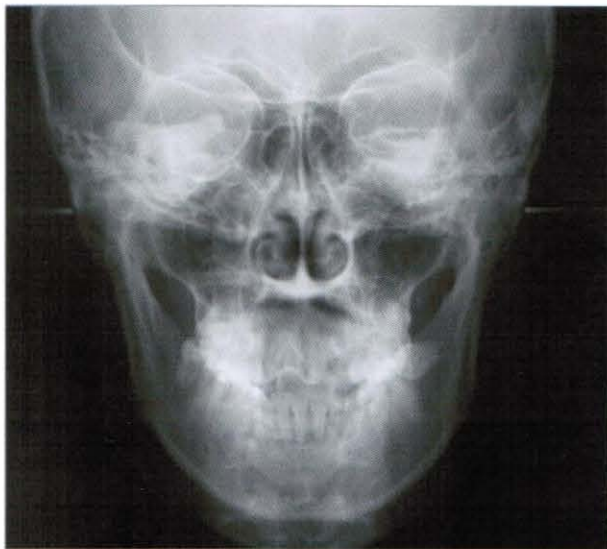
Postero-anterior radiograph
